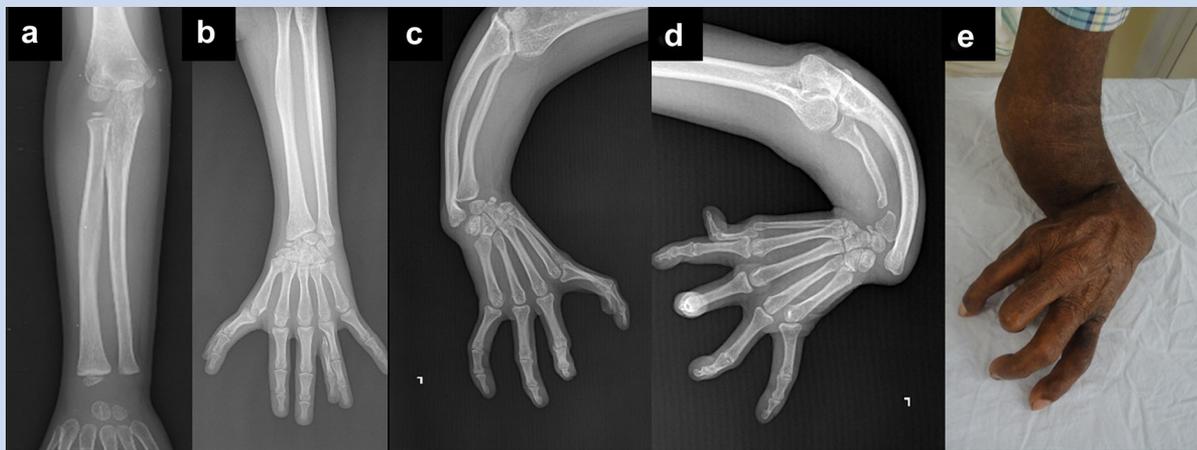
Radiographs of the forearm showing normal forearm (Individual III:18) (a), mild radius bowing (Individual IV:2) (b), moderately bowed small radius and a small ulna (Individual III:14) (c), and a small radius with bowing of the ulna (Individual II:5) (d). Clinical photograph of radial deviation of hand (Individual II:5) (e).
